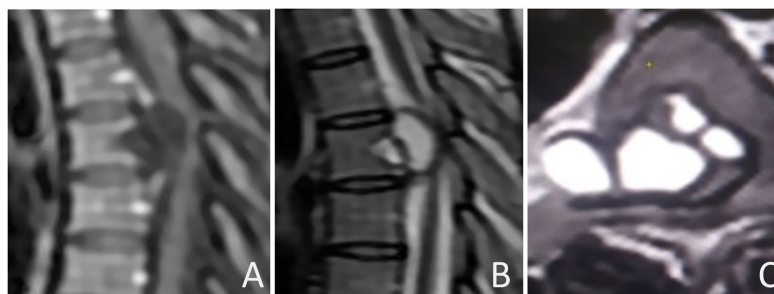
MRI suggests a T1 hyposignal process in the sagittal section (A), T2 hypersignal in sagittal section, axial section (B, C), multi-vesicular, with extension to the body and the posterior arch of T4. This process extends inside the medullary canal, resulting in spinal cord compression.
